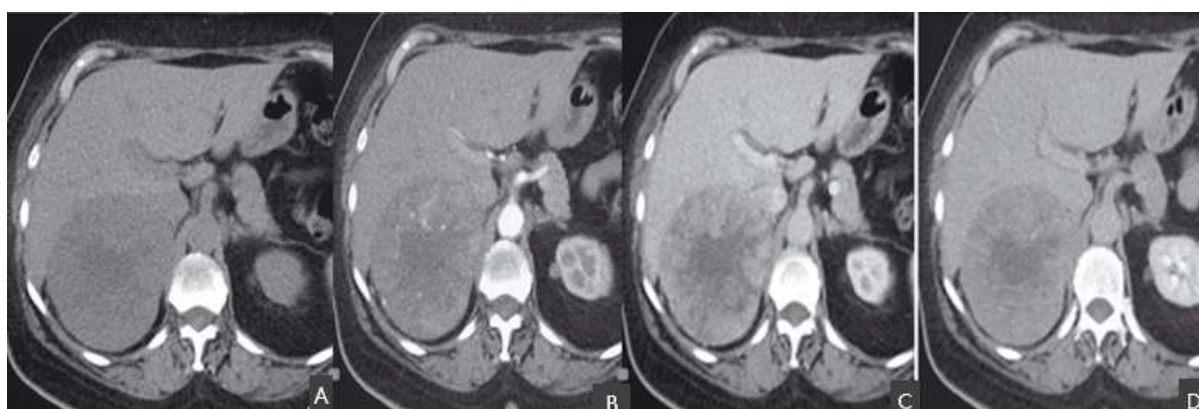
CT Washout Analysis: (A) Unenhanced phase, (B) Portal phase, (C) 15-minute delay showing rapid clearance (>60%)
